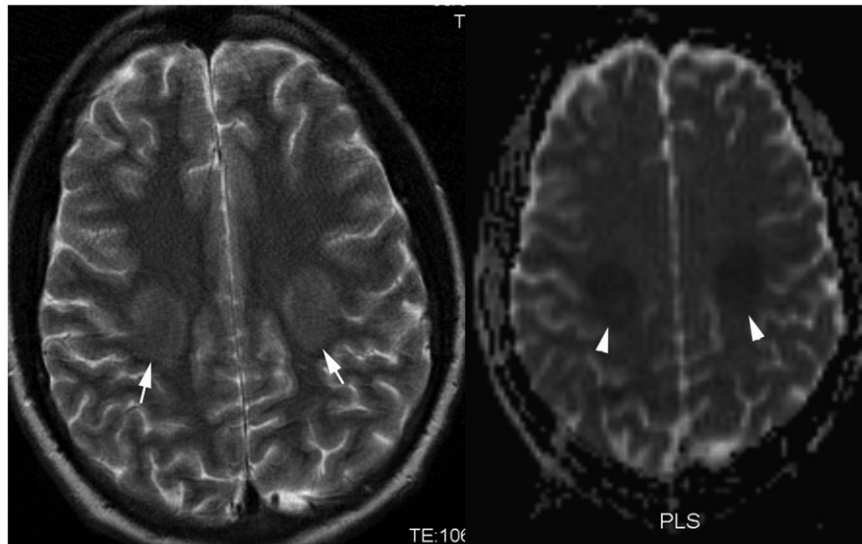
Methotrexate leucoencephalopathy. Axial T2-weighted MRI (TR 4350, TE 106 ms) showing hyperintense foci within both centra semiovale (short arrows), with corresponding restricted diffusion on apparent diffusion coefficient map (arrow heads).
